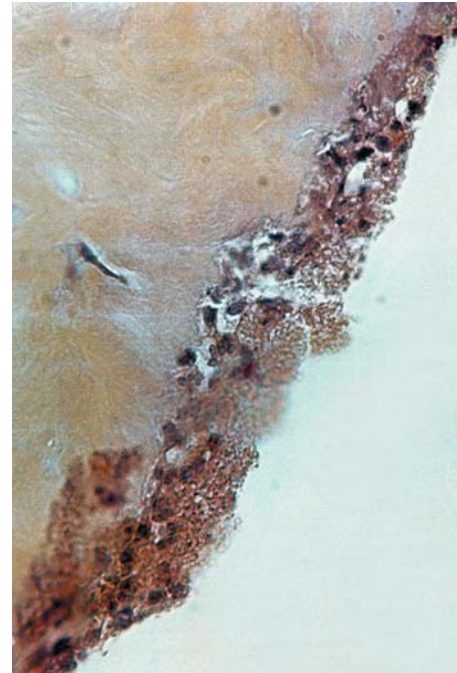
Amplification of the rectangle area in Figure 6. Periapical biofilm of predominantly gram-negative microorganisms, Brown & Brenn - 1000X
